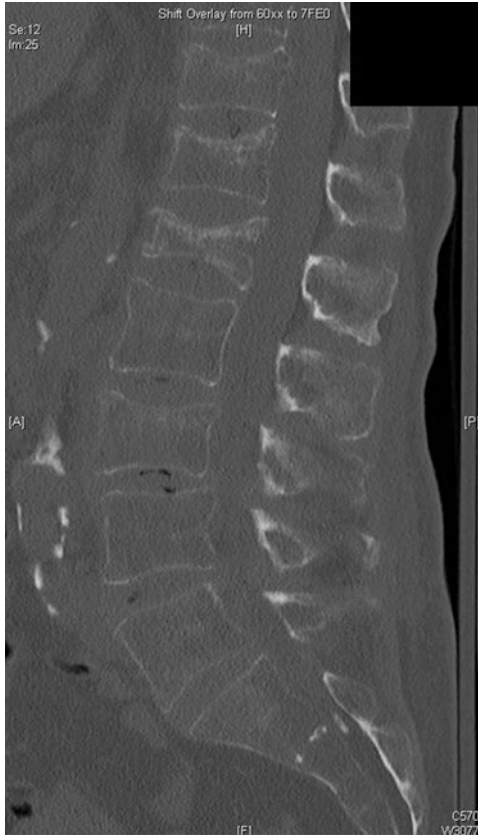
A compression fracture of the spine demonstrated on a CT scan. Note the low density of the bone on this image, suggestive of osteoporosis
